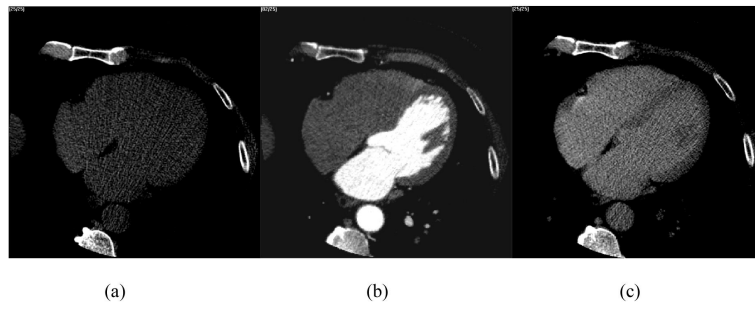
Three phases cardiac CT images. (a) Pre-contrast image; (b) CT angiography image; (c) Post-contrast Image.
